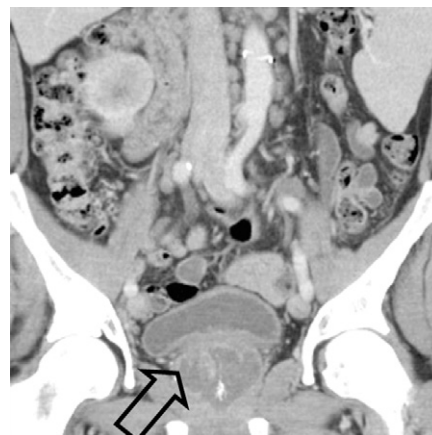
Prostate abscess. Contrast-enhanced CT scan, coronal view: intraprostatic collection (arrow) with no sign of perineal diffusion.
